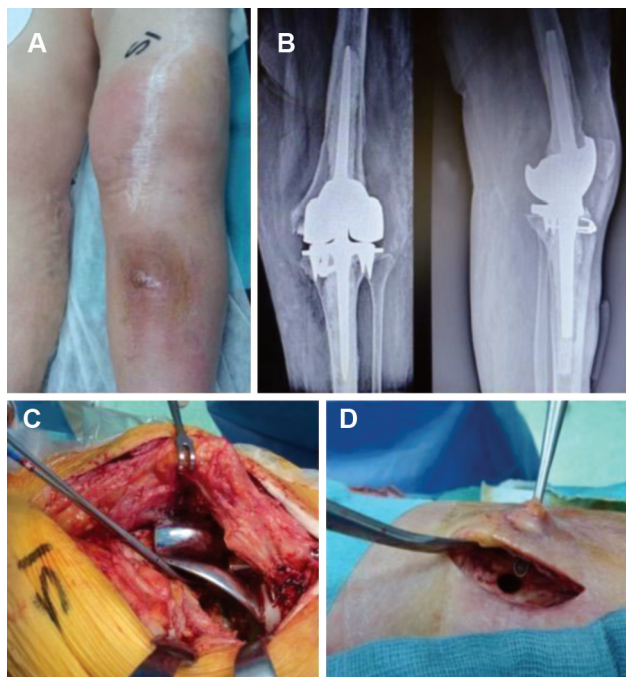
Panel A: Clinical presentation in May 2010 of the acute, late, haematogenous infection of the left cemented knee joint prosthesis; Panel B: Antero-posterior and lateral X-ray views at the time of infection occurrence; Panel C: Intra-operative evidence of peri-prosthetic infection and osteolysis at the joint level; Panel D: Mid-shaft tibial bone fistula in communication with the skin.
